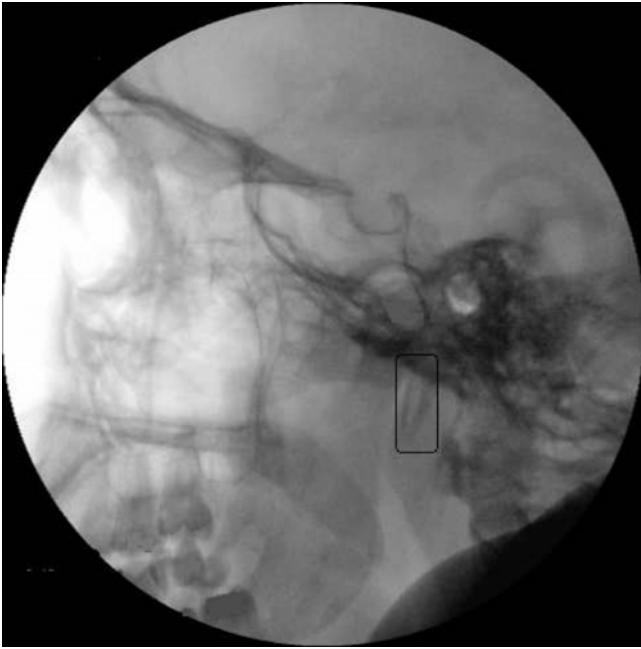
X-ray image of the styloid process (*outlined*) (Image courtesy of Andrea Trescot, MD)
